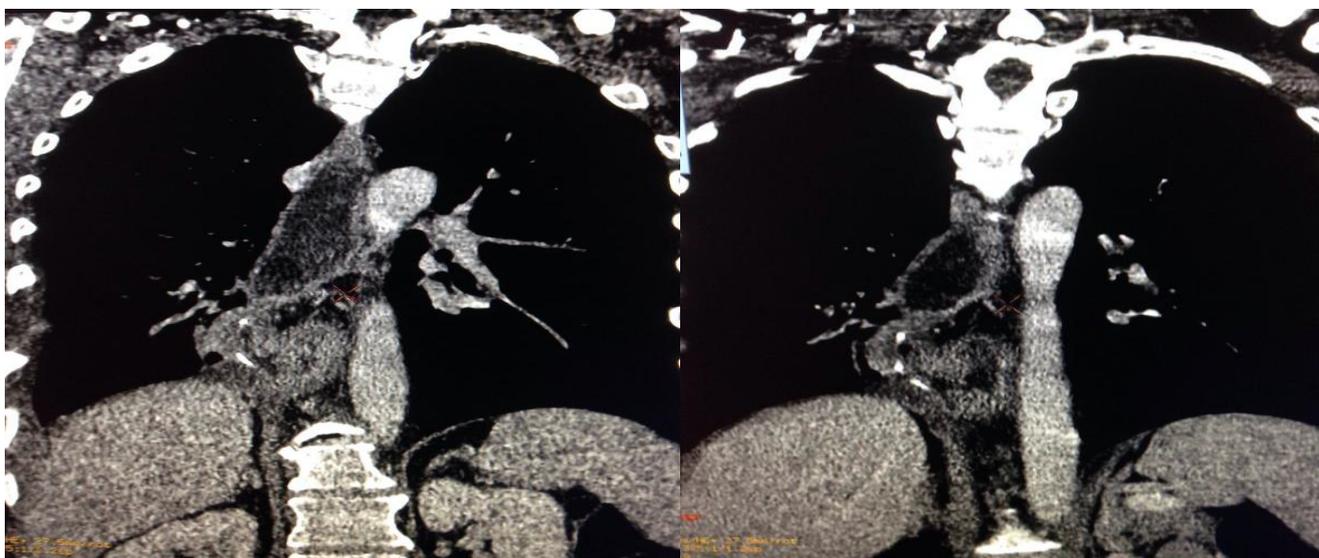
Chest CT scan: esogastric anastomosis after the stent removal; there are no signs of recurrence 18 months postoperatively.
